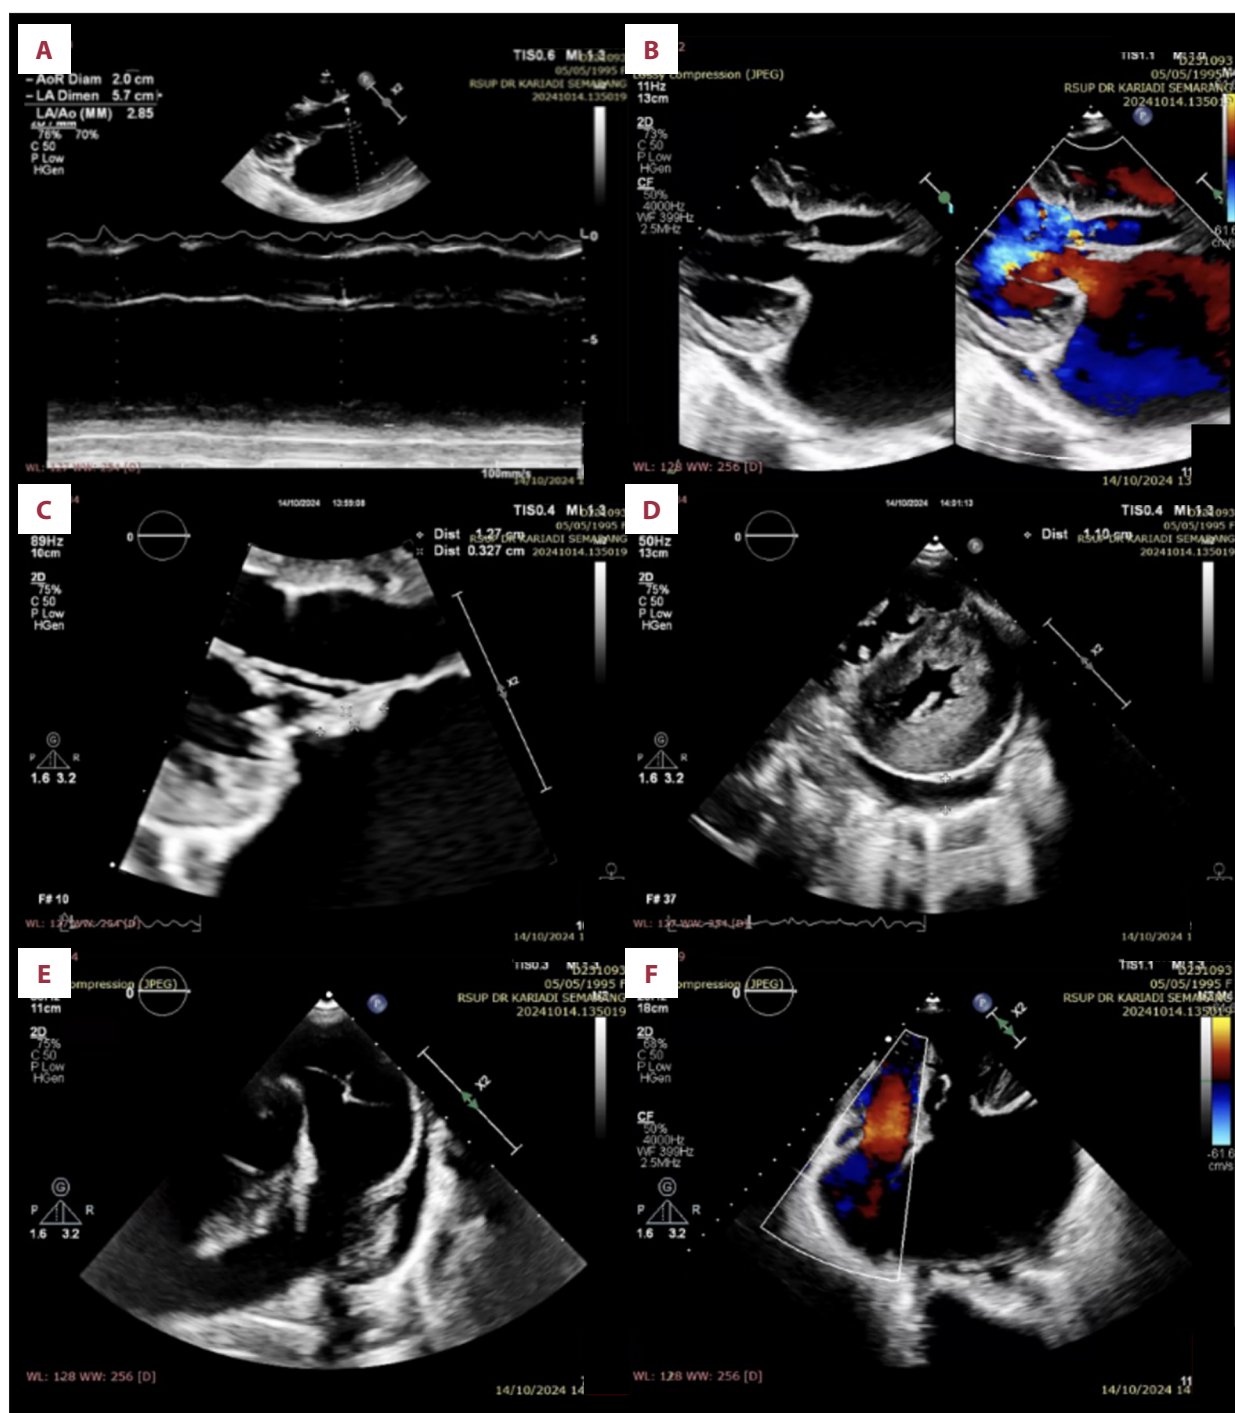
Echocardiogram showing mitral regurgitation with vegetations and pericardial effusion. (A) Dilated left atrium and eccentric left ventricular hypertrophy with a left ventricular ejection fraction (LVEF) of 69.9%. (B) Severe mitral regurgitation due to a flail anterior mitral leaflet (AML) with an oscillating mass on the AML. (C) Oscillating mass (+) on the AML measuring 1.2 x 0.3 cm. (D) Left ventricle (LV) showing a D-shape during systole and diastole. The LV was globally normokinetic. Loculated pericardial effusion was visible posterior to the LV. (E) A mass was present in the right ventricular outflow tract, suspected to be vegetation, pedunculated, measuring 1.3 x 0.6 cm. The main pulmonary artery was dilated. (F) Moderate tricuspid regurgitation (TR), TR vena contracta 0.3 cm, TR Vmax 2.4 m/s, MaxPG 23 mm Hg.
